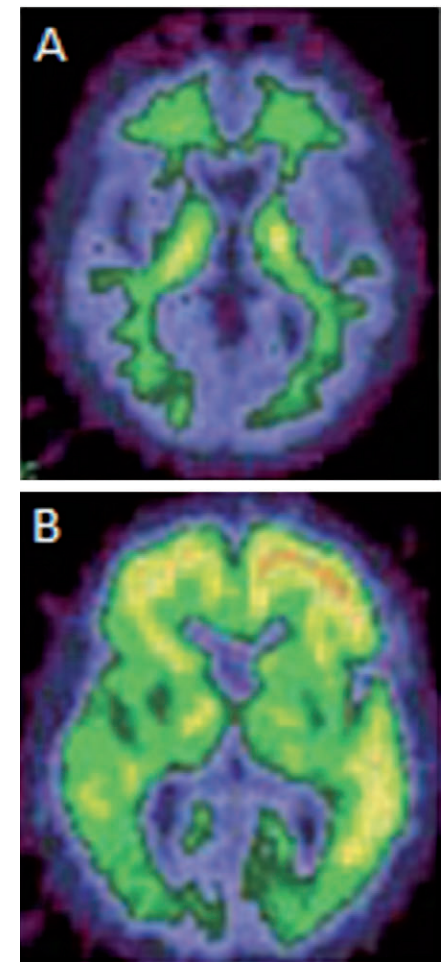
Examples of amyloid positron emission tomography-computed tomography in a healthy geriatric subject (A) and in a patient with Alzheimer's disease (B).
